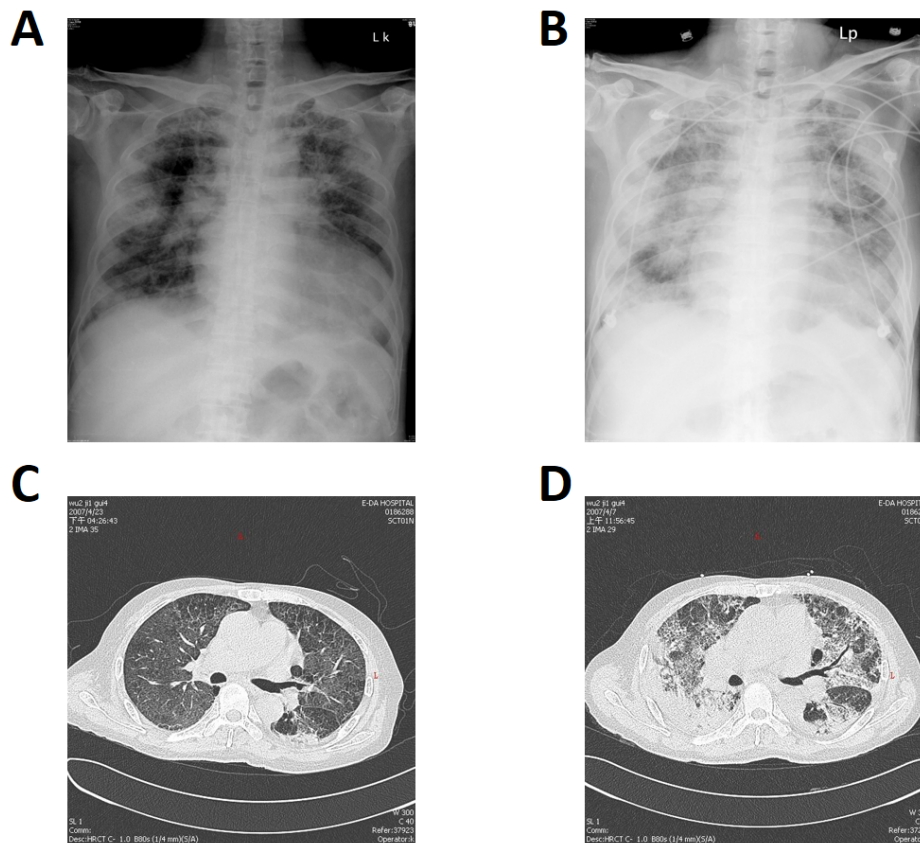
(A) Initial chest x-ray of our patient, which showed multiple patches in bilateral peripheral lung fields. (B) Subsequent chest x-ray at ICU, which showed rapid progression of the pulmonary lesions despite discontinuation of amiodarone and treatment with moxifloxacin. (C) HRCT before corticosteroid treatment, which showed alveolar and interstitial opacities with diffuse distribution in bilateral lung fields. The attenuation of the opacities wasn't significantly increased. (D) Subsequent HRCT after corticosteroid treatment for 18 days, which showed almost complete resolution of the lesions.
